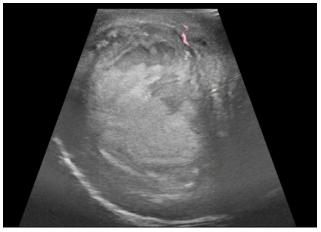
Sonogram of the right testicle demonstrating partially confluent curvilinear areas of hypoechogenicity, which demonstrate no significant vascularity
